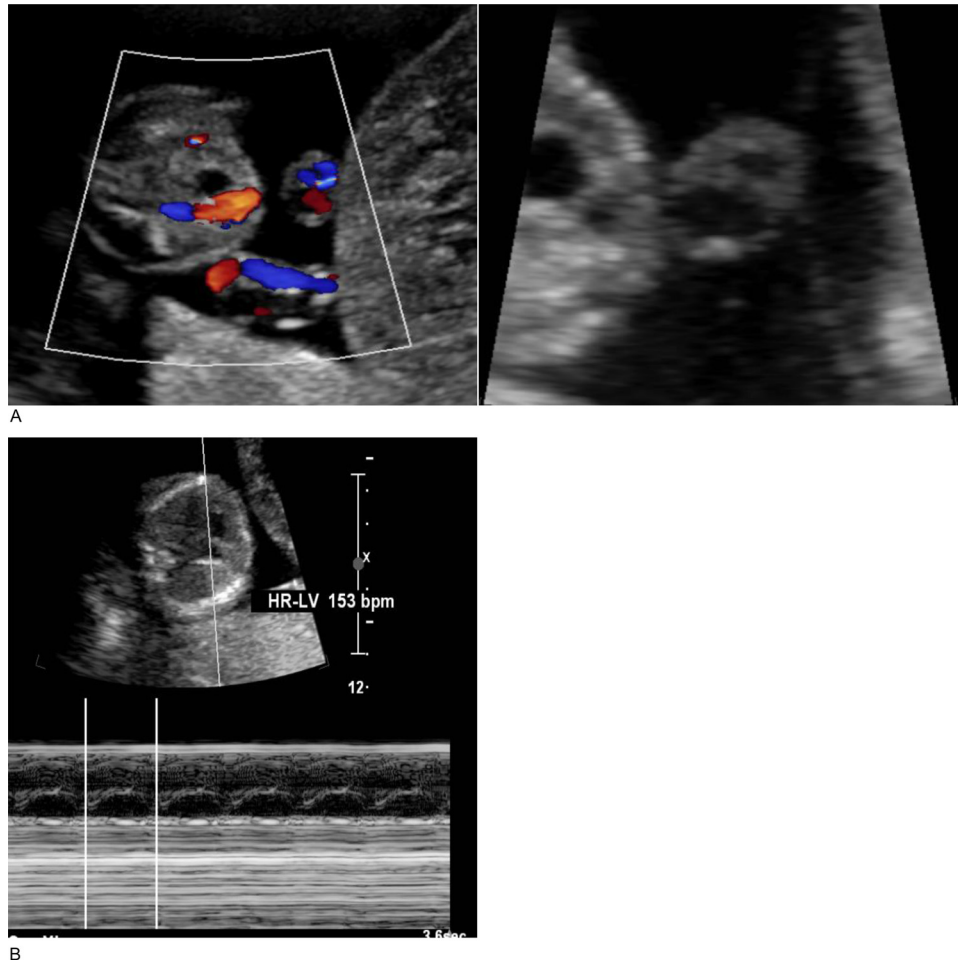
(A) Single umbilical artery demonstrated by color doppler and in transverse grayscale imaging. (B) Twin A normal heart rate by M-mode.
